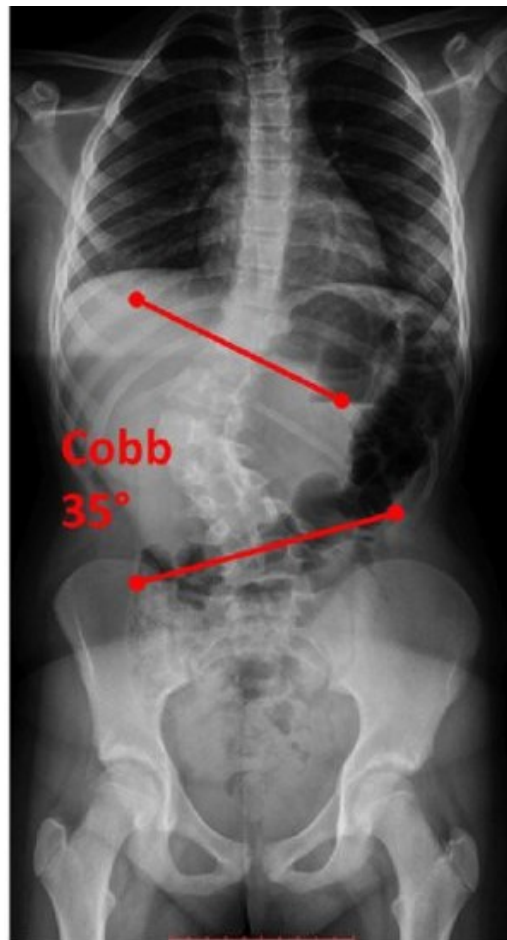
CT scan of a patient suffering from scoliosis with a healthy pelvis eligible for this study.⁵⁷
